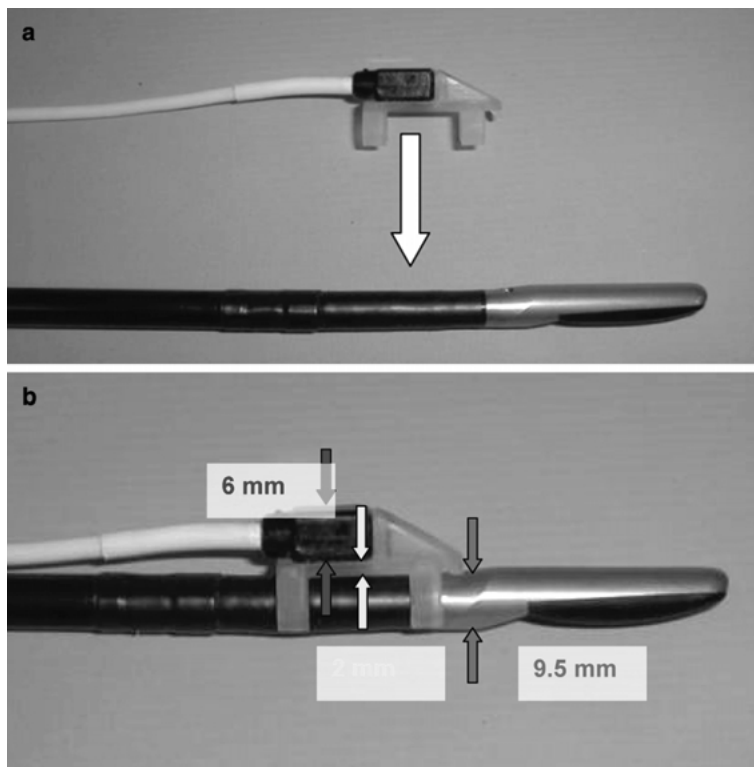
a Adapter with mounted tracking sensor placed as near as possible to the tip of the laparoscopic ultrasound probe. b Adapter with mounted tracking sensor at the head of the laparoscopic ultrasound probe. The total diameter of the system is 17.5 mm.
